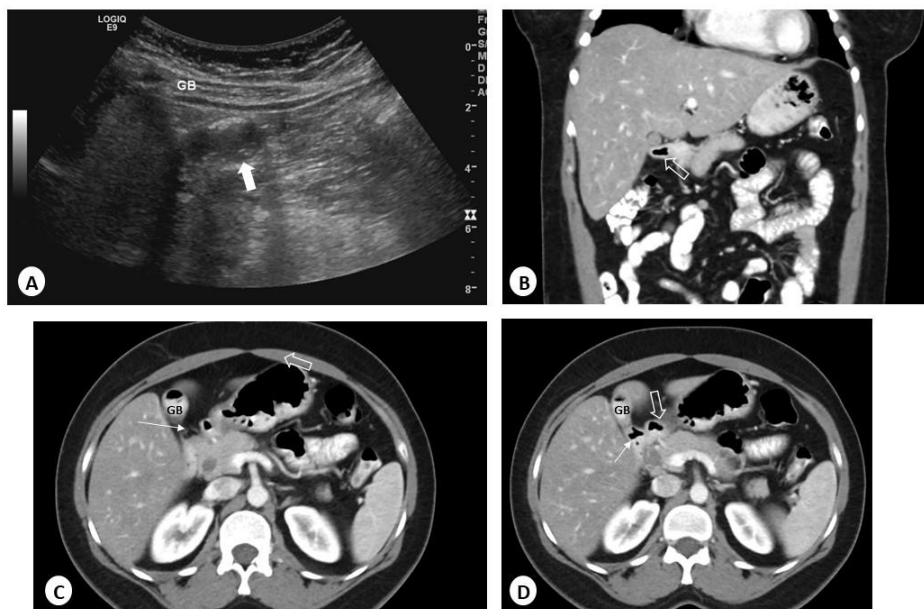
A. transabdominal US showing gallbladder (thick arrow) reverberation artifact in its upper part suggestive of air. B(Coronal),C&D(Axial) contrast enhanced CT showing the gallbladder (GB) filled with oral contrast with air present within it. The fistula (arrow) identified connecting the gallbladder with duodenum (open arrow) suggestive of cholecystoduodenal fistula.
